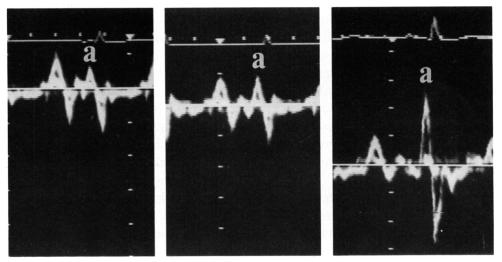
Left atrial appendage Doppler velocity profiles at 3 min (left), 10 min (middle) and 72 h (right) after cardioversion in a 67-year old man. An increase in the peak velocity of the left atrial appendage "a" wave, corresponding to increased left atrial appendage contraction, was noted after cardioversion.
